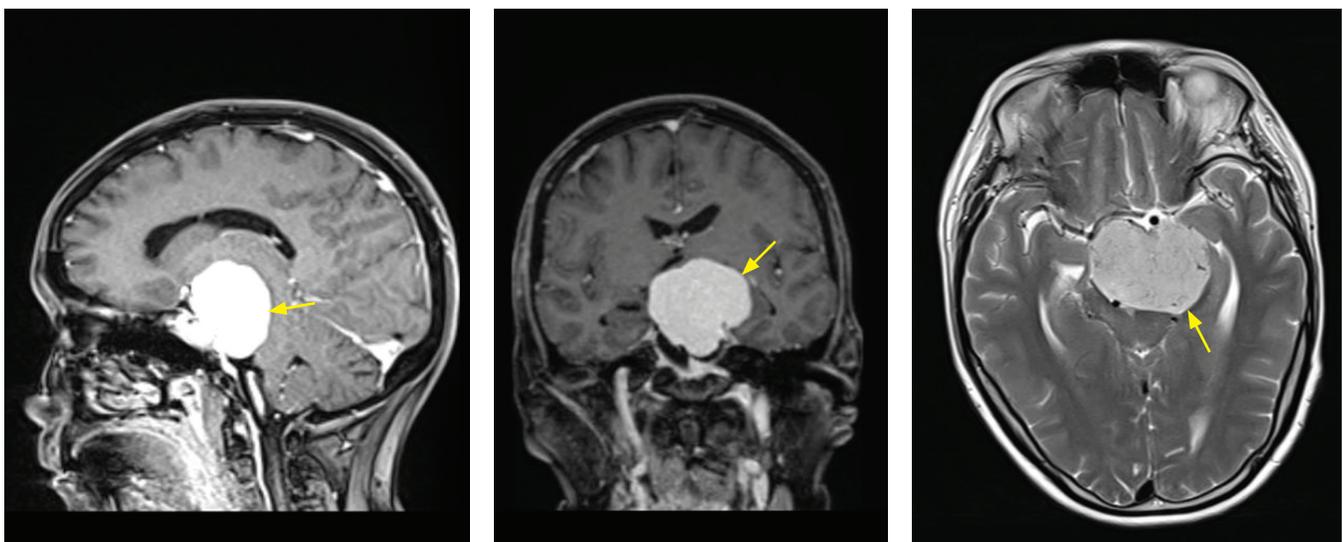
Selected sagittal, coronal, and transverse slices of the contrast-enhanced magnetic resonance imaging showing the petroclival meningioma (yellow arrows).
